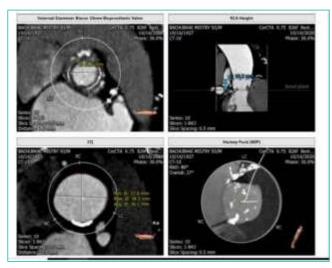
CT aortogram showing various dimensions of the aortic root
